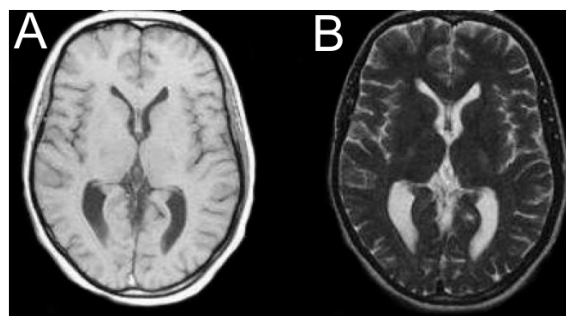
Image weighting. (A) T1-weighted images depend primarily on TR, and recovery of longitudinal magnetization. (B) T2-weighted images depend primarily on TE and the amount of decay in the transverse plane. Figures from revisemri.com
